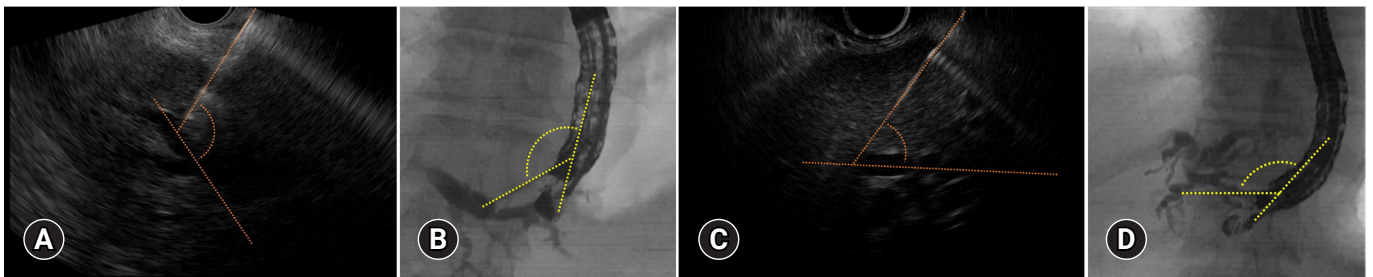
Measurements of the puncture angle between the fine needle and intrahepatic bile duct on the endoscopic ultrasound (EUS) images (A, C), and the puncture angle between the fine needle and echoendoscope (B, D) on the fluoroscopic images. Successful guidewire manipulation cases: The puncture angle was obtuse (110°) on the EUS image (A) and was also obtuse (135°) on the fluoroscopic image (B). Unsuccessful guidewire manipulation cases: The puncture angle was acute (55°) on the EUS image (C) and was also obtuse (135°) on the fluoroscopic image (D).
